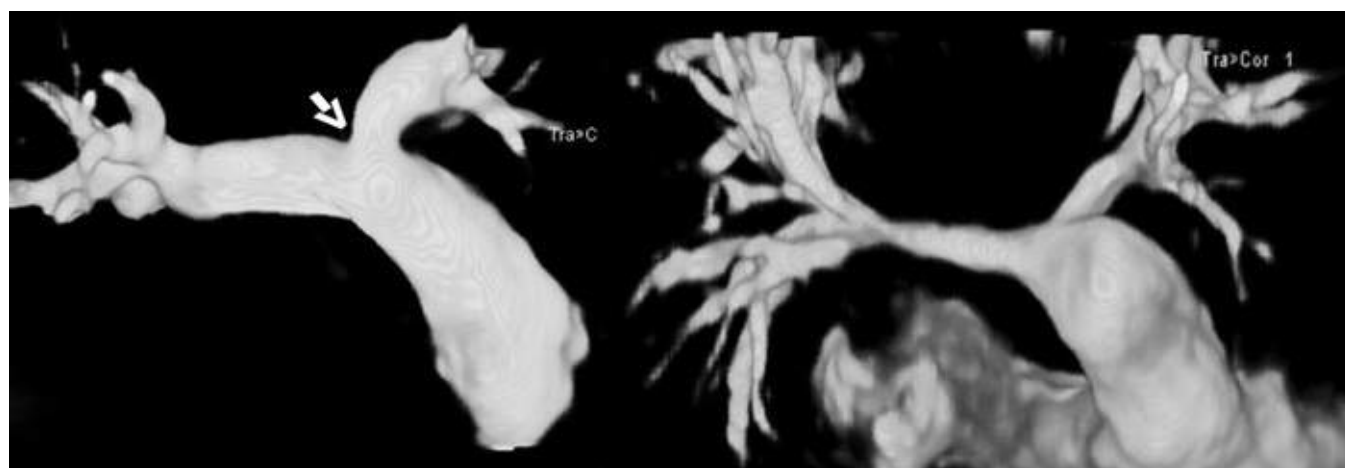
This panel shows two cases with peripheral pulmonary artery stenosis as seen by MRI. The one on the left shows a central proximal left pulmonary artery stenosis, and the right panel shows a case with diffuse stenosis of both branch pulmonary arteries.
